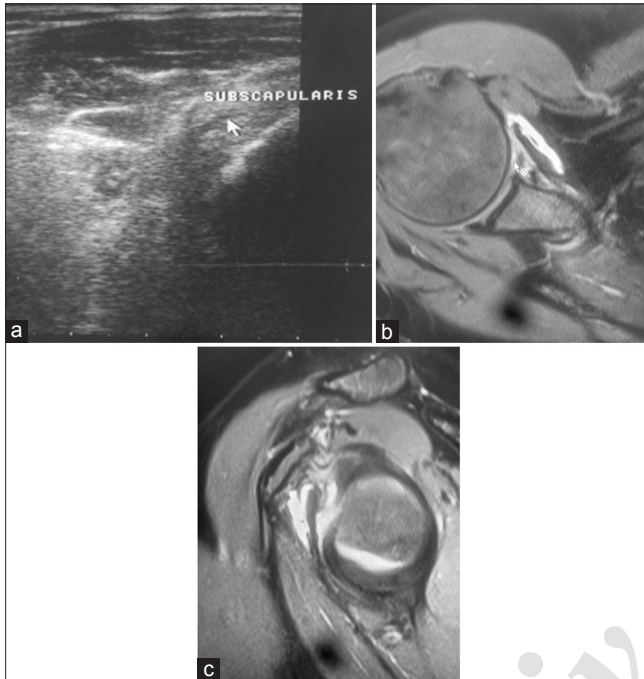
(a) Longitudinal ultrasound image showing hypoechoic defect in subscapularis tendon suggesting partial tear. (b and c) Axial and oblique sagittal PD-weighted images showing hyperintense signal involving subscapularis tendon representing partial tear
